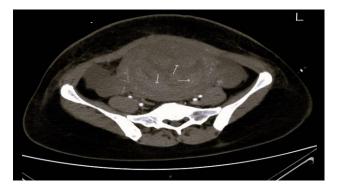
CT abdomen with contrast. (Arrow marks represent haemorrhagic products filling endometrial cavity).
